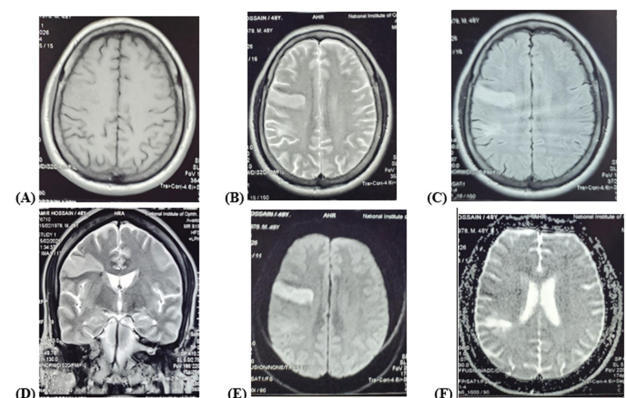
Case Of Acute Ischemic Stroke at Right Frontal Lobe, Lesion Isointense on T1WI, Hyperintense on T2WI & FLAIR, High Signal on DWI & Low Signal On ADC.
